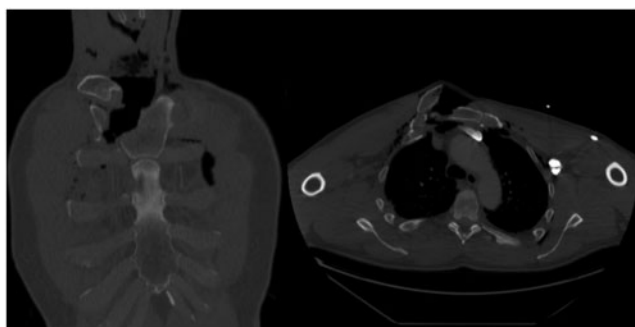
Preoperative computed tomography of sternal fracture.
